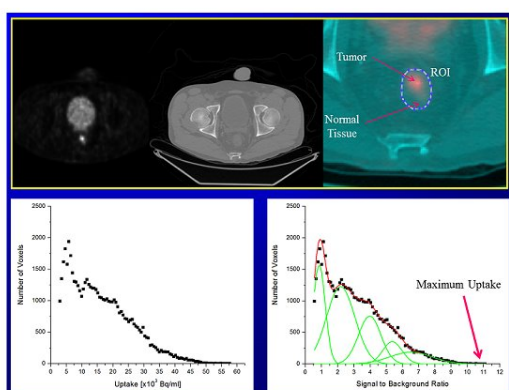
Sampling of FDG uptake within rectal tumor and normal rectal tissue (top); differential Uptake Volume Histogram (dUVH) in terms of uptake values (bottom-left); dUVH normalized to the uptake value of the first peak assuming to represent normal rectal tissue glucose uptake (bottom-right).
